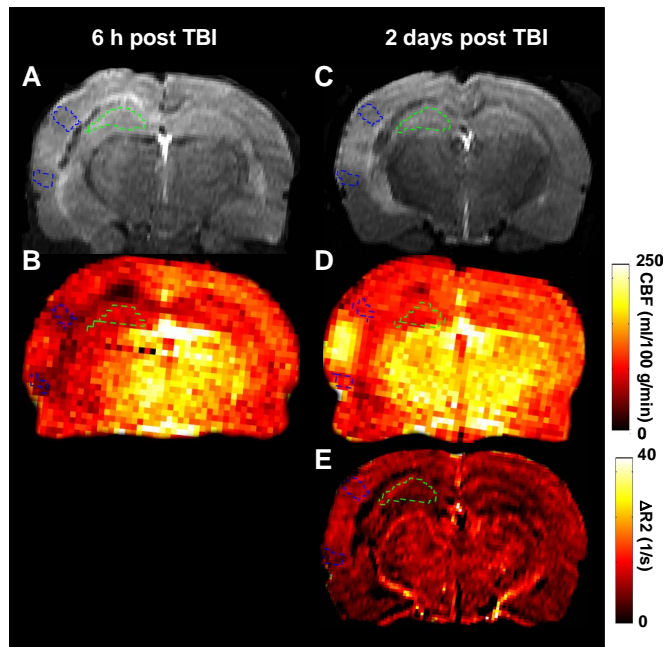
Representative MR images and quantitative maps acquired after TBI. The green outline encapsulates the ipsilateral hippocampus and the blue outline surrounds the perifocal area. A) T₂ weighted image acquired 6 h after TBI. B) CBF map acquired 6 h after TBI. C) T₂ weighted image from 2 days after TBI. D) CBF map acquired 2 days after TBI. E) CBV map calculated 2 days after TBI.
